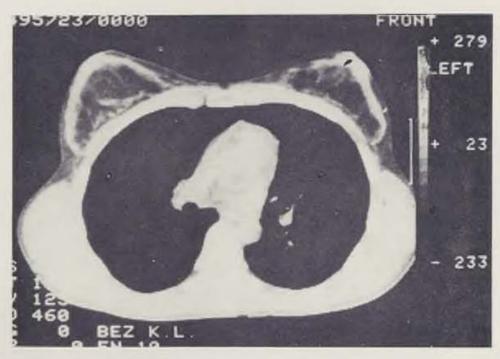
Patient B. V. CT check-up 5 years after corio-adipose implant surgery. A minimum of contraction or calcification
